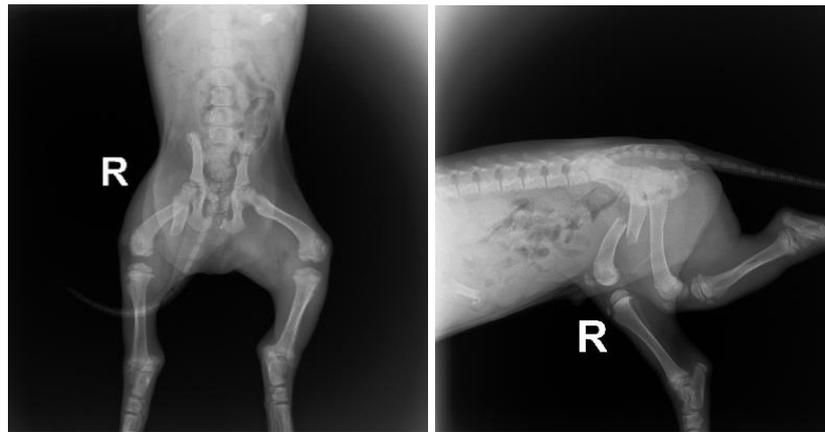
Preoperative radiographic examination showing ventrodorsal (left) and lateral (right) views, revealing an oblique fracture of the right femur.
